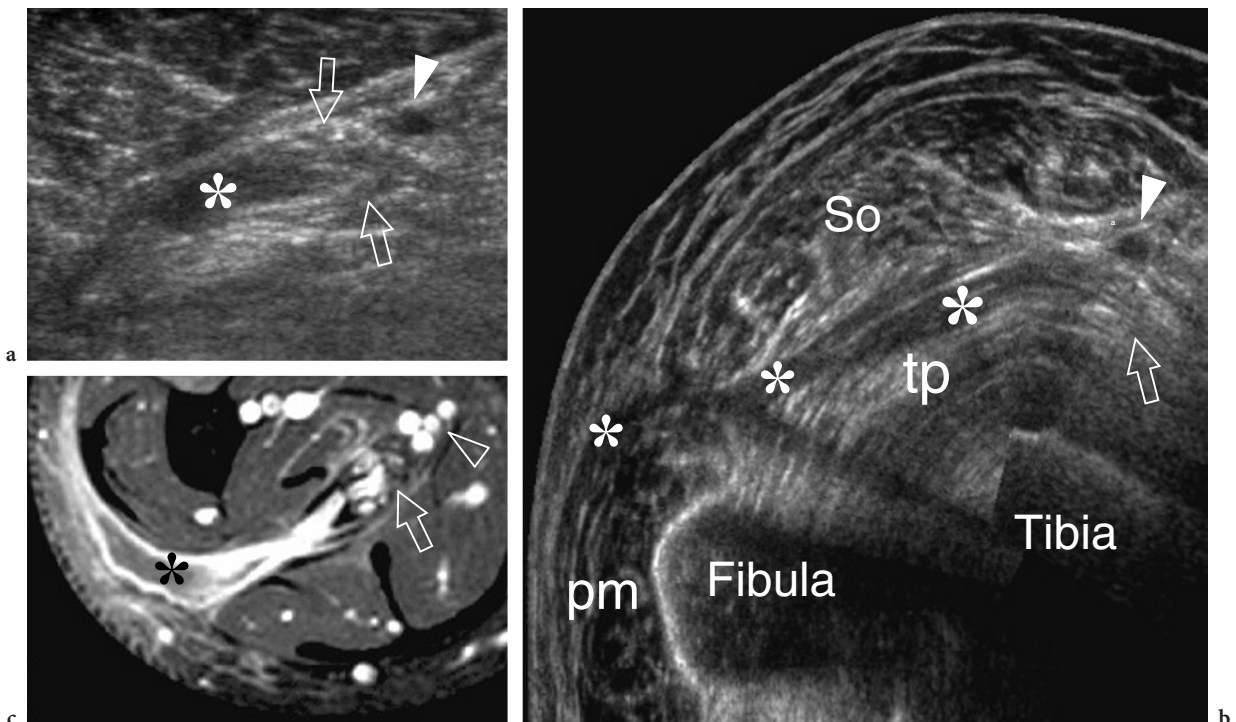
Neurogenic abscess in leprosy. a Transverse scan and b extended-field-of-view 12–5MHz US images over the tibial nerve (arrows) at the mid-distal third of the leg demonstrate a fluid collection (asterisk) arising from the nerve substance and spreading along the fascial planes, deep to the soleus muscle (So) and superficial to the tibialis posterior (tp) and the peroneals (pm). c Correlative Gd-enhanced fat-suppressed MR image shows discrete contrast enhancement in the abscess walls. Note the origin of the abscess from the nerve. Arrowhead, posterior tibial vessels. Aspiration of fluid revealed aseptic necrotic material
